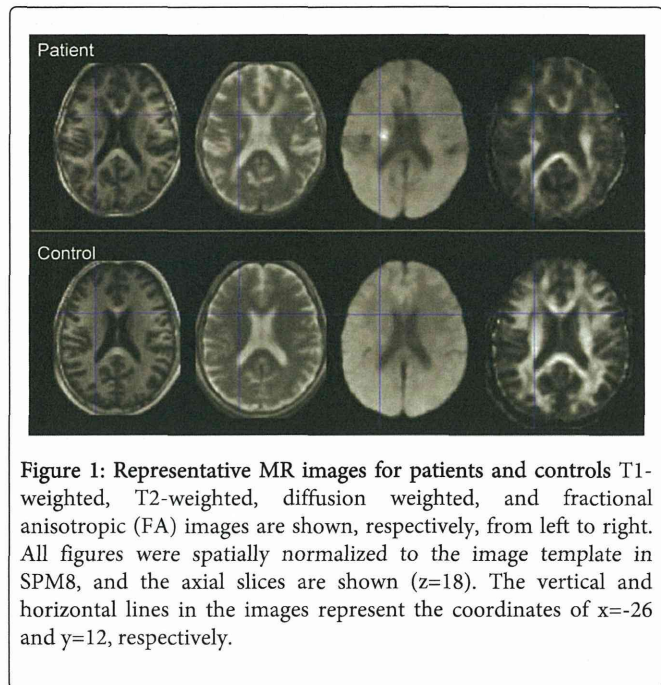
Representative MR images for patients and controls T1-weighted, T2-weighted, diffusion weighted, and fractional anisotropic (FA) images are shown, respectively, from left to right. All figures were spatially normalized to the image template in SPM8, and the axial slices are shown (z=18). The vertical and horizontal lines in the images represent the coordinates of x=-26 and y=12, respectively.
